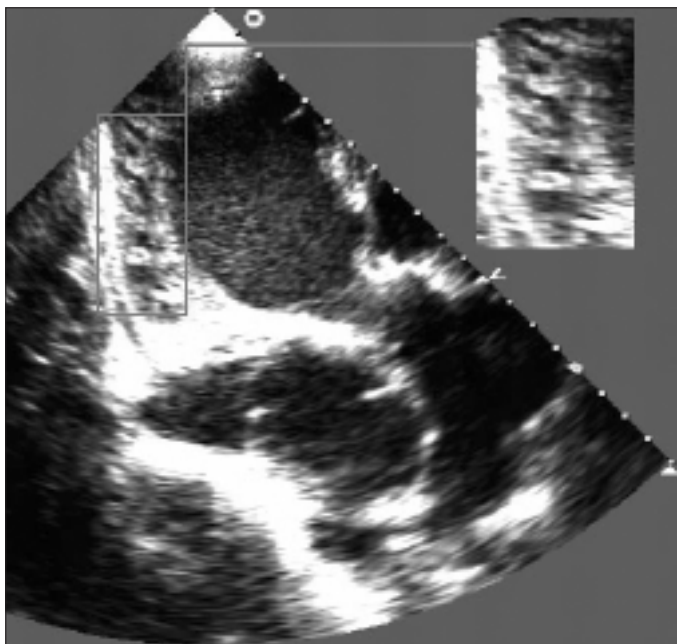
Two-dimensional echocardiography view of multiple prominent myocardial trabeculations
